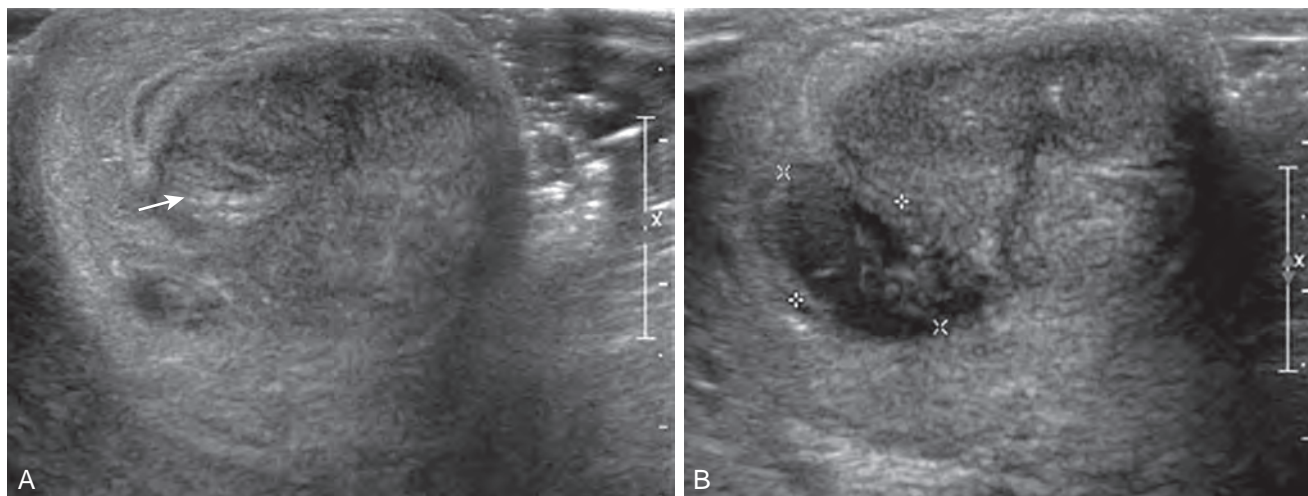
A, Ultrasound examination demonstrates ruptured tunica albuginea (arrow) in a patient with a suspected penile fracture. B, Hematoma adjacent to ruptured tunica.
